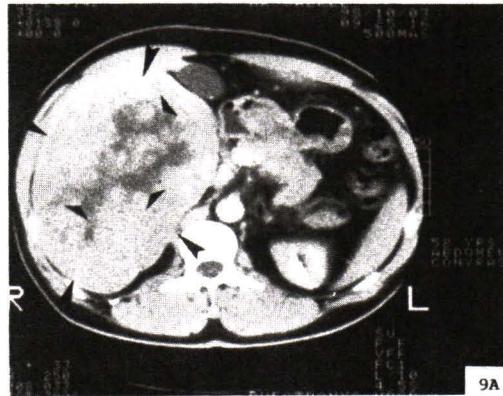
Contrast enhanced CT scan of liver shows a big necrotic hepatocellular carcinoma. (big arrow head) The small arrow points to the center of necrosis.
